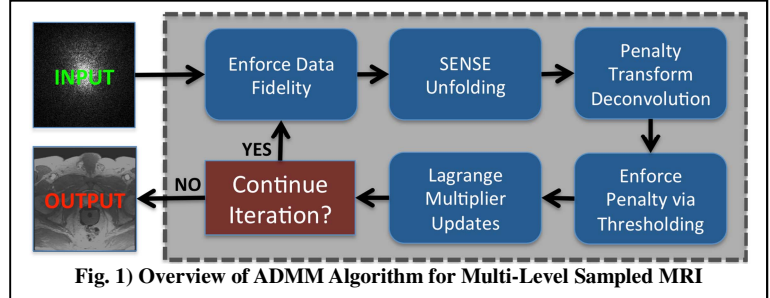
Overview of ADMM Algorithm for Multi-Level Sampled MRI
